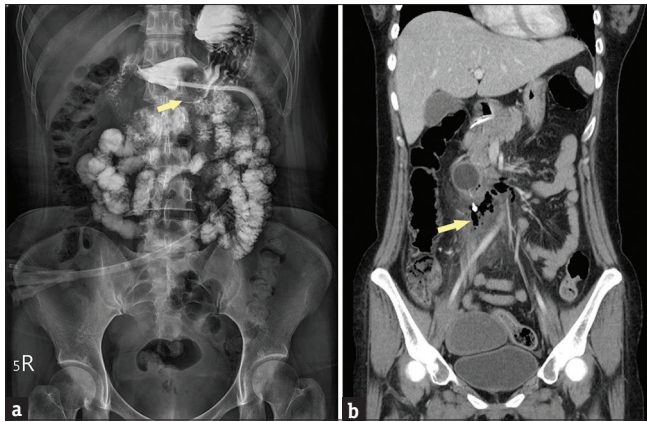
(a) Abdominal radiography showing the contrast medium from gastrostomy passing through the small intestines. The balloon of the Foley tube was found in the antrum of the stomach (arrow). (b) Computed tomography showing the balloon of the Foley tube that advanced to second portion of the duodenum. Free air and fat stranding were noted around the tip of the Foley tube (arrow), leading to suspicion of duodenal perforation
